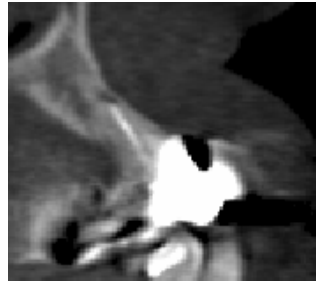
Periapical radiolucency related to tooth #6
